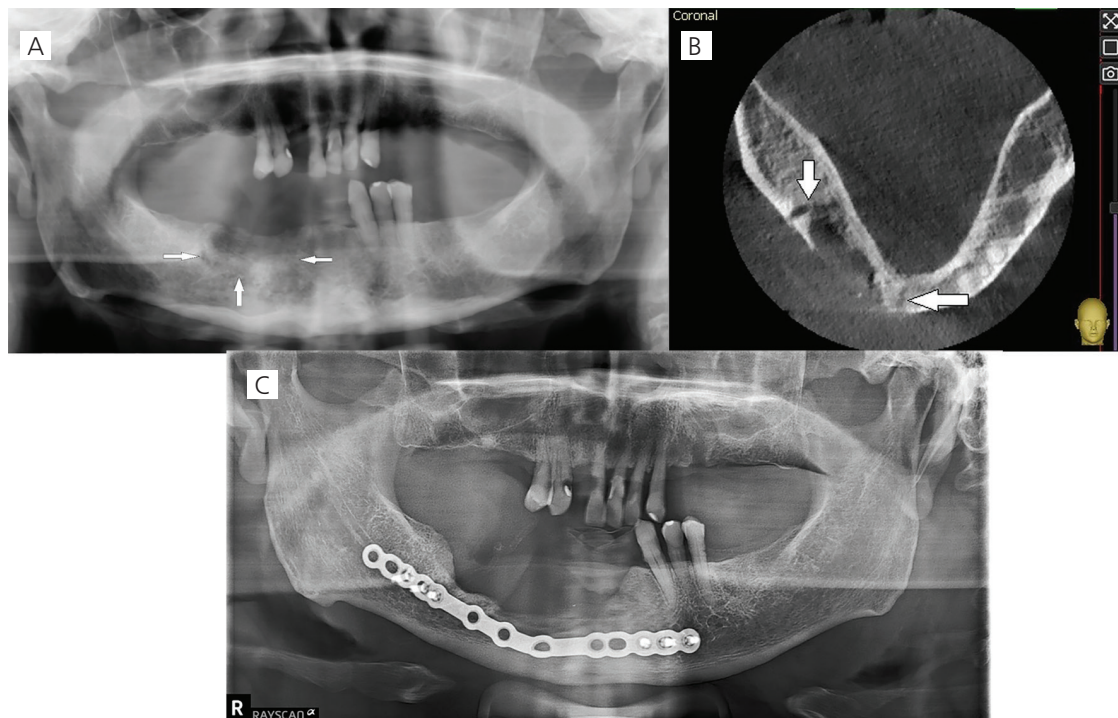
Radiological presentation of Case 1, A) Preoperative orthopantomography, B) Dental volumetric tomography axial section, C) Postoperative orthopantomography
